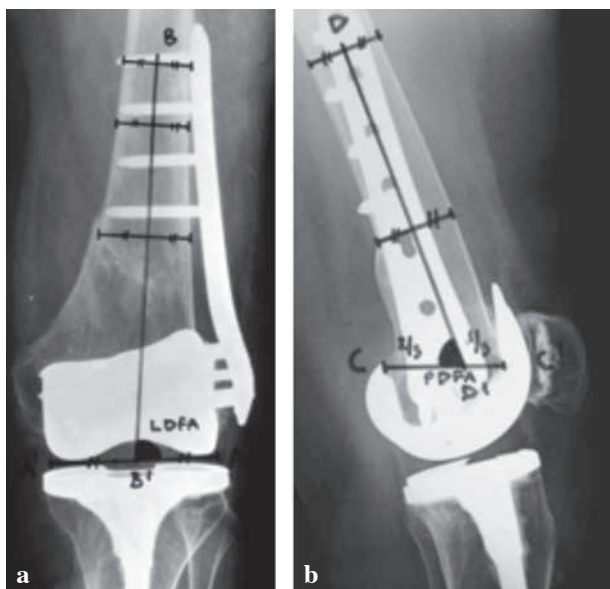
The alignment of the femoral component was evaluated using the anatomic lateral distal femoral angle (aLDFA) (Angle between A-A and B-B line) (a) and the anatomic posterior distal femoral angle (aPDFA) (Angle between C-C and D-D line) (b) measured on plain radiographs. Normal values for these parameters were accepted as 81° (range 79° to 83°) and 83° (range 77° to 88°) respectively.
